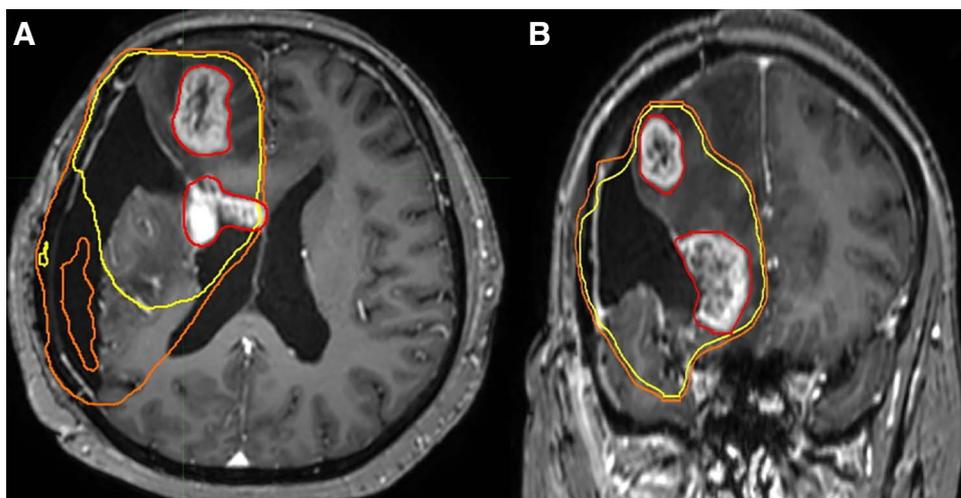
The analysis of recurrence pattern. (A) Axial enhanced T1 weighted image (B) Coronal enhanced T1 weighted image. Axial enhanced T1-weighted image at the first recurrence was fused with computed tomography of radiotherapy planning. All the recurrent masses were contoured by 1 radiation oncologist. The volumes of recurrent mass (red line) within 95% isodose line (57 Gy, yellow line) and 90% isodose line (54 Gy, orange line) of prescription dose (60 Gy) were analyzed. The patient showed central recurrence (more than 95% of recurrence volume was in 95% isodose line [IDL] of prescription dose [60 Gy]).
